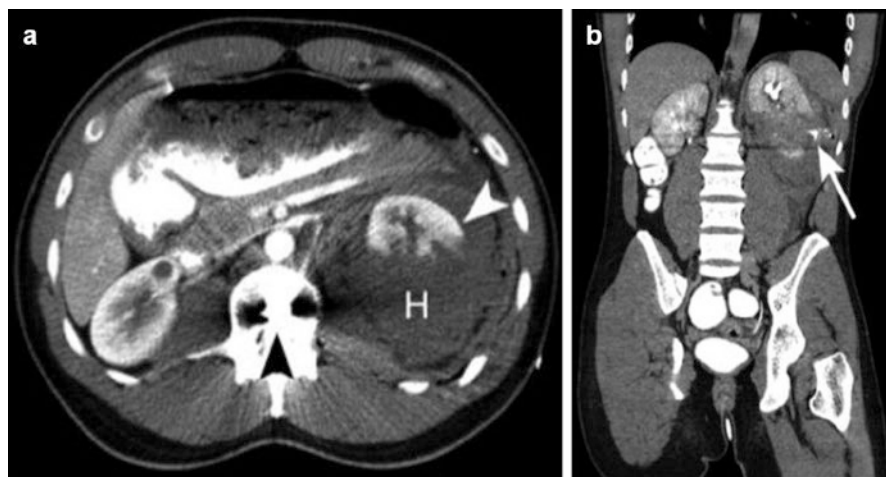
Penetrating trauma right Grade IV renal laceration with collecting system injury [14]. (a) Axial postcontrast CT during the nephrographic phase in a patient presenting after gunshot wound to the left flank. The image shows a deep laceration through the inferior aspect of the left kidney (*arrowhead*), large perinephric hematoma (H), and a bullet fragment lodged in the vertebral body. (b) Coronal CT during the excretory phase demonstrates extravasation of contrast (*arrow*) from a tear in the collecting system
